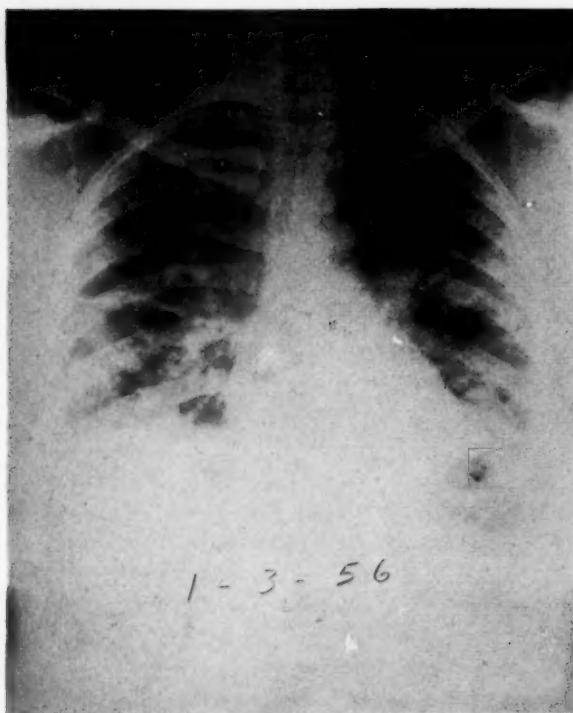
Chest roentgenogram, posteroanterior view, January 3, 1956.
